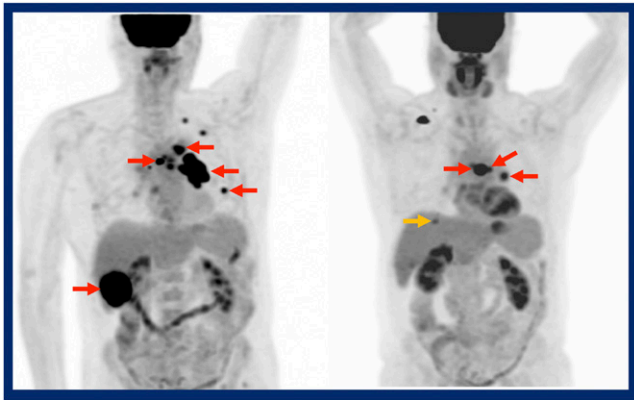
^{18}F -FDG PET/CT for monitoring immunotherapy with PD-1 blockade in patients with advanced non-small cell lung cancer (NSCLC). Example PET/CT images in a patient with advanced NSCLC at baseline (left) and on follow-up PET (right) show target lesions (red arrows) and new false-positive lesion (yellow arrow at follow-up). Using PERCIST, the patient would have been classified as having progressive metabolic disease. Using imPERCIST, the patient was classified as having a partial metabolic response. The use of PERCIST for assessment in this 50-patient study indicated progressive metabolic disease in 39, whereas the use of imPERCIST indicated progressive disease in only 21. Overall survival, however, was not correlated with differences in tumor response prediction in the 2 criteria. Visualizing a new lesion after immune-checkpoint treatment initiation does not necessarily imply worse outcomes.
